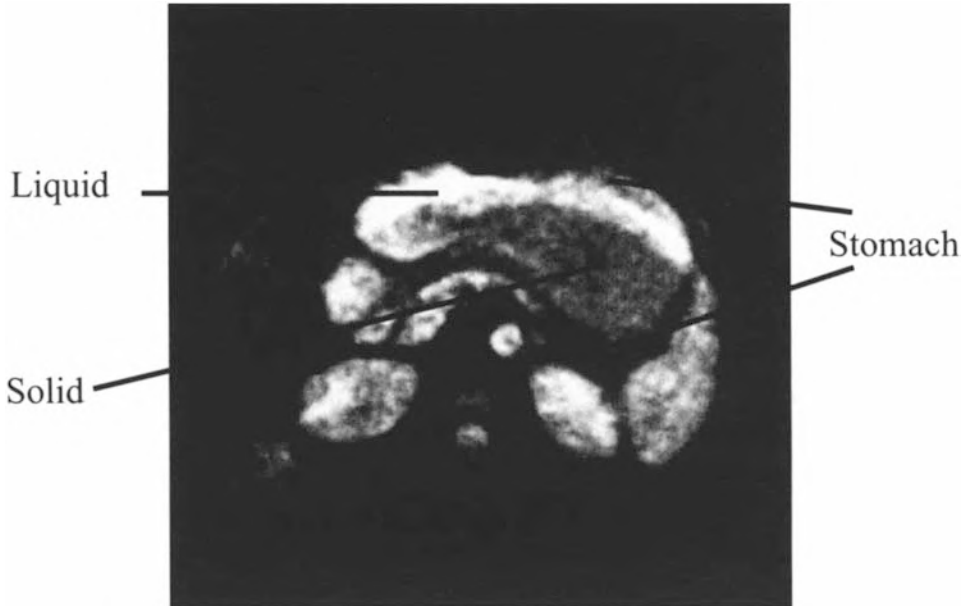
MRI cross section through the body. The large organ at the top is the stomach, which clearly shows the liquid layer (white) floating on the solid (grey) matter
